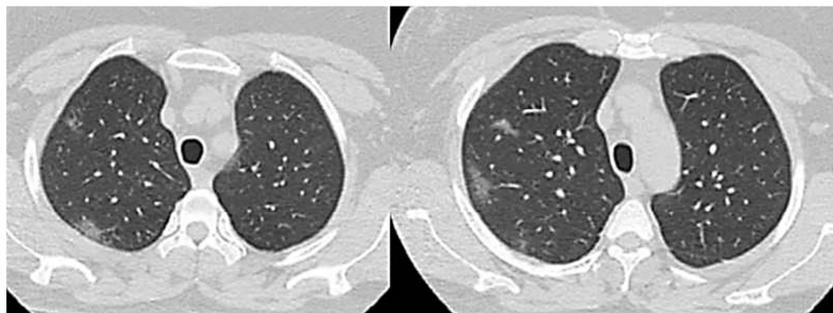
54-year-old female patient with COVID-19. The CT was performed on day 3 of COVID (phase 1), observing ground glass opacities as the only pattern.
